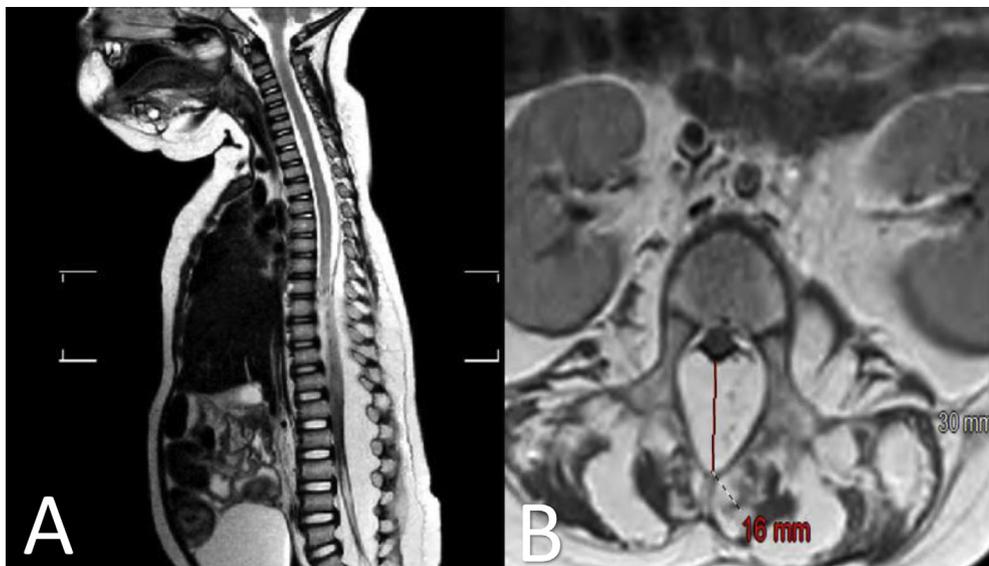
T2-weighted sagittal view (A) and T1-weighted axial view (B) of magnetic resonance imaging of the spine demonstrating homogeneously hyperintense fatty tissue in the posterior aspect of the spinal canal of maximum thickness 16 mm, causing thecal sac compression with obliteration of the subarchanoid space from T6 to S3 level, maximal across lumbar spine and sacral spine. The color version of this figure is available in the online edition.
